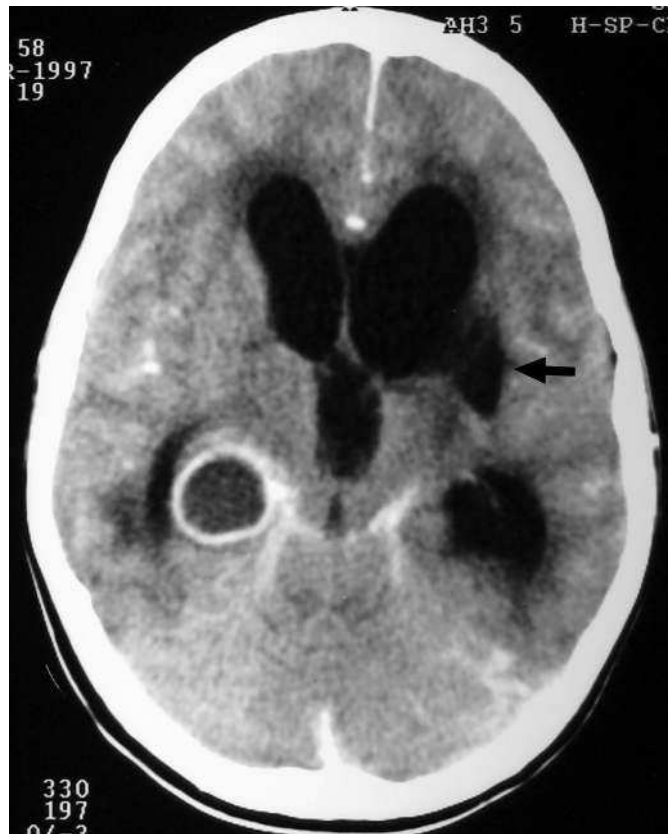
Postcontrast axial CT scan showing dense basal exudates around the quadrigeminal cistern, hydrocephalus, right parahippocampal tuberculous abscess, and a left basal ganglia infarct (arrow).
